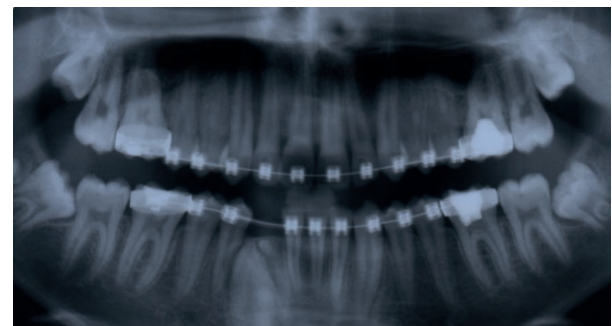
Pre-intervention radiograph.
